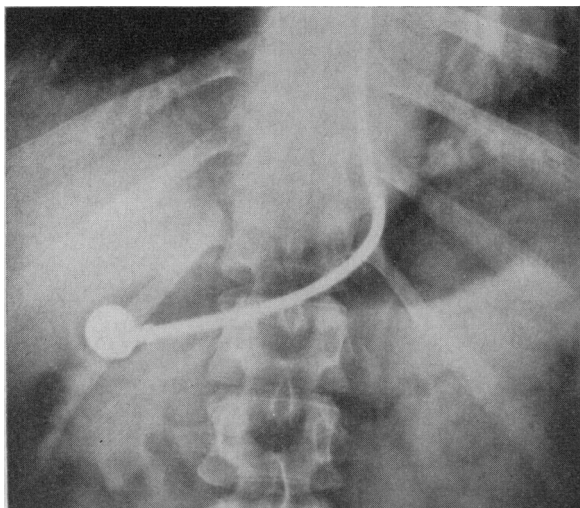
Air contrast roentgenogram of the stomach showing the biopsy capsule in the prepyloric region.
